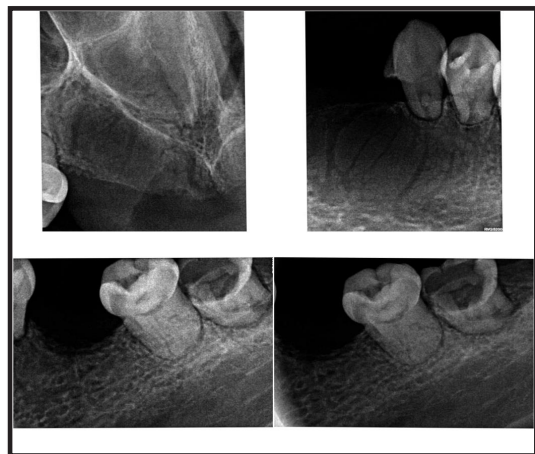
Intraoral radiographs of female patient
